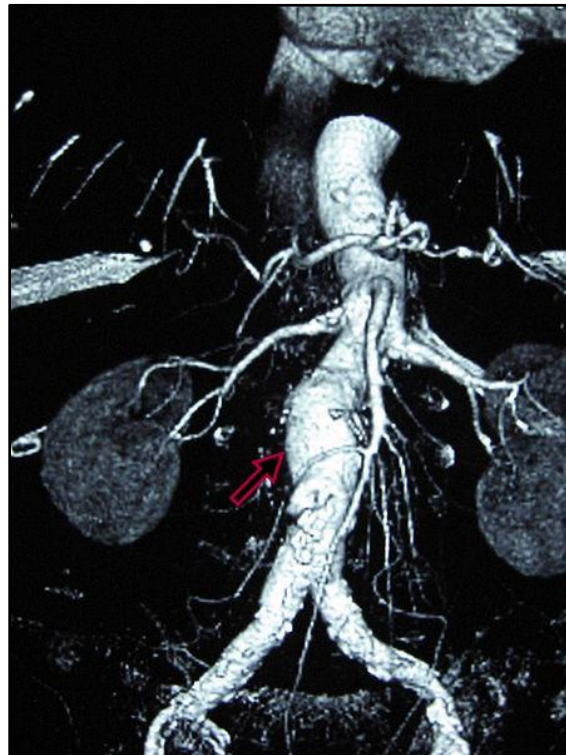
AAA, shown on the Multi-Slice Computed Tomography (MSCT), surface rendering (the patent lumen is filled with contrast, while the real aneurysm size can be deduced by noticing the wall calcifications producing an egg-shell semilunar appearance, to the left of the visible lumen).
